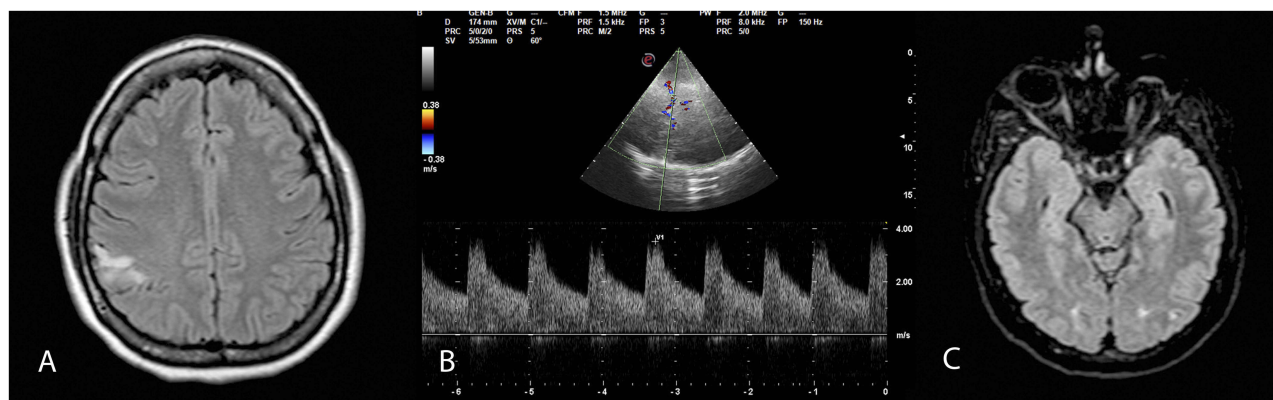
Brain MRI scan of the study subject at the time of admission. (A) Right fronto-parietal cortico-subcortical hyperintensity in fluid-attenuation inversion recovery (FLAIR) axial images. (B) TCCD revealing increased blood flow velocity (mean value: 210.2 cm/s) with turbulence in the right MCA segment, indicative of vasospasm. (C) Control brain MRI showing newly developed bilateral occipital focal hyperintensities in FLAIR axial images, indicative of ischemic stroke.
